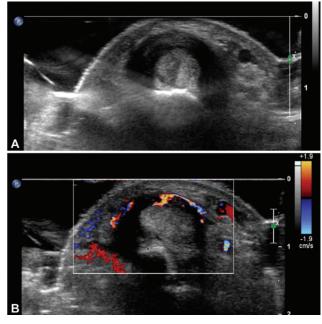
(A, B) De Quervain disease with hypoechoic thickening of the extensor retinaculum of the first extensor tunnel and increased Doppler signal.
